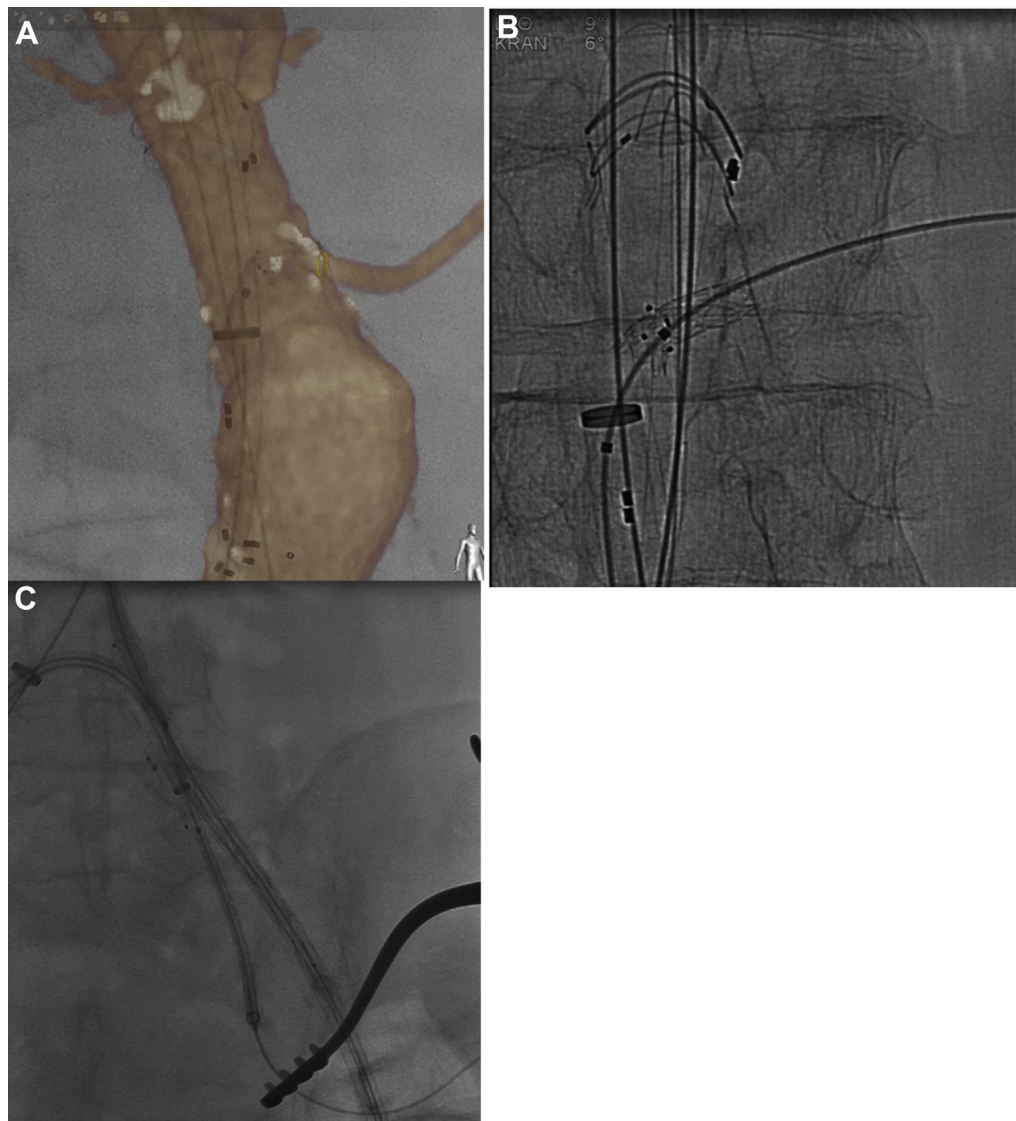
(A) A digitally generated overlay IF shows a good position of the fenestrated stent graft in the infrarenal aorta with the stent in the left additional renal artery through the fenestration. (B) High resolution X-ray
